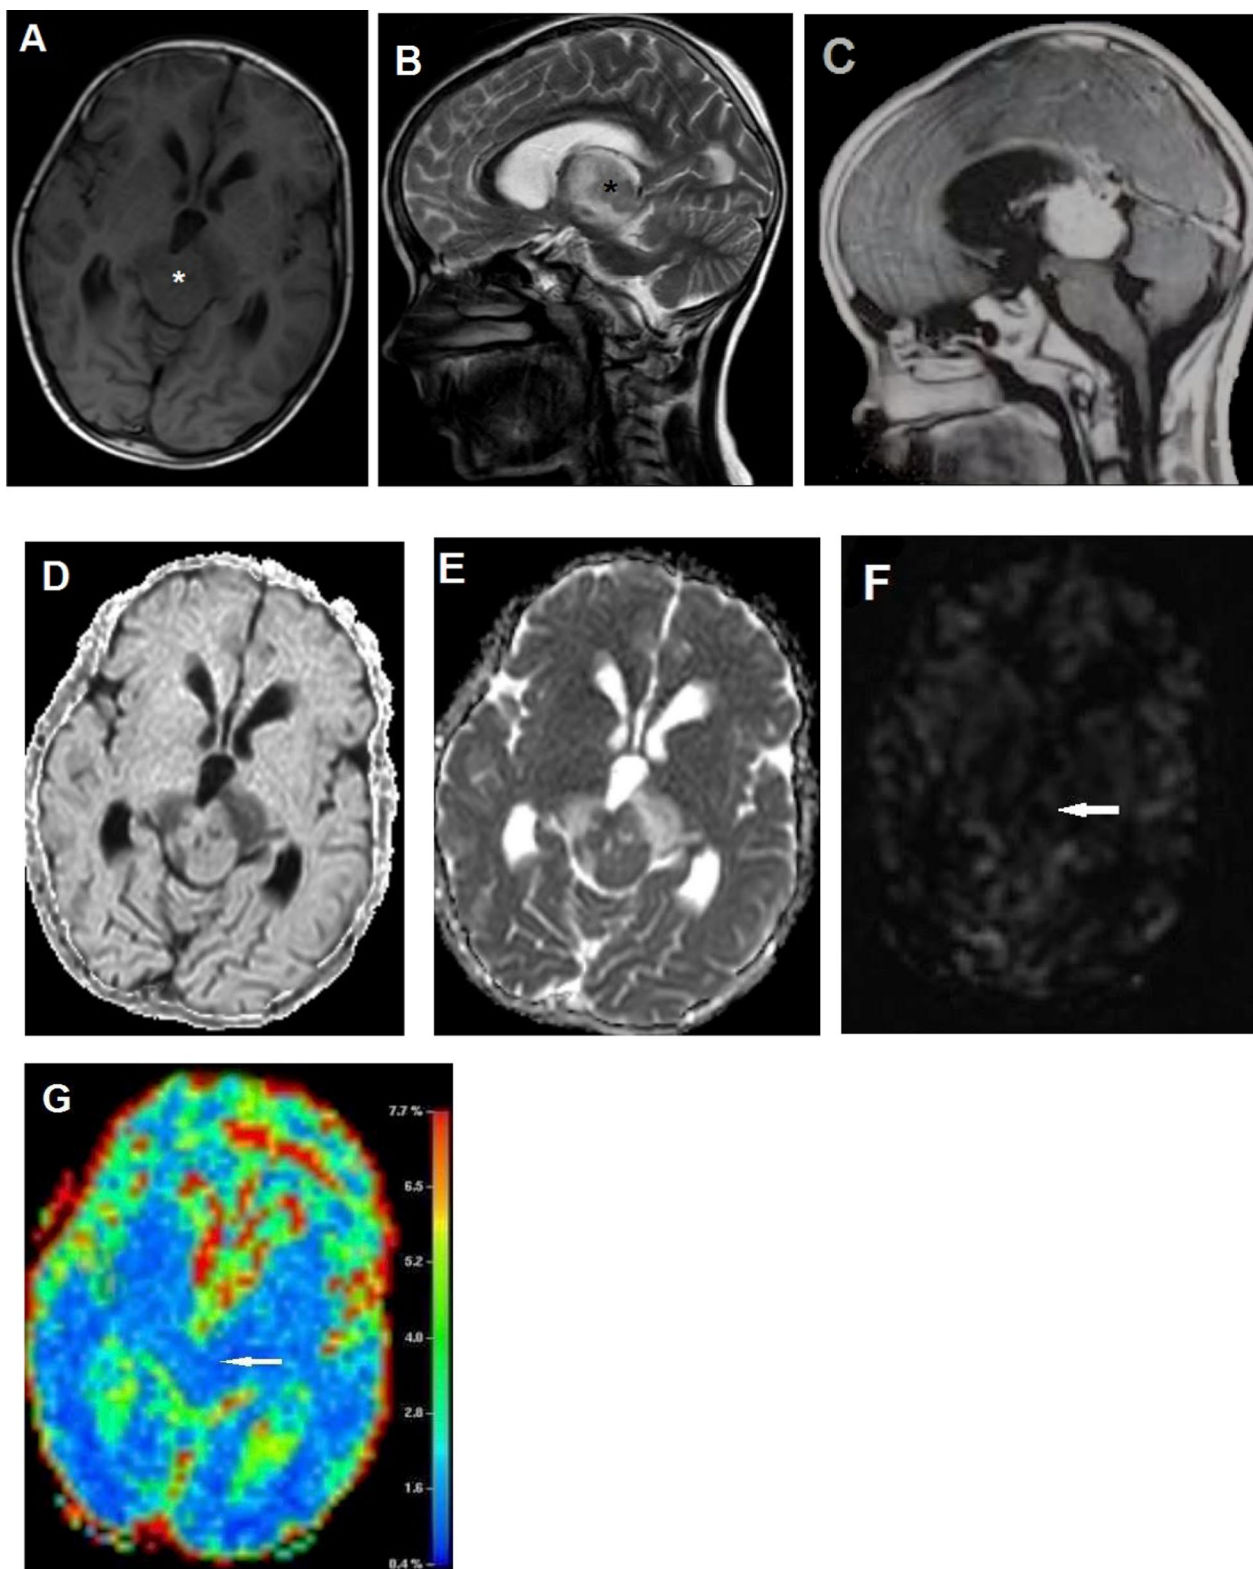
A 10-year-old boy patient with a WHO grade 2 pineal body tumor of intermediate differentiation. Images show a well-defined pineal body lesion with supra-tentorial hydrocephalic changes. It displays low signal intensity on axial T1WI (A) and intermediate to high SI with high SI perilesional edema on sagittal T2WI (B). It shows strong homogenous enhancement on post contrast sagittal T1WI (C), the lesion shows free diffusion as shown on both DWI (b1000 image) and axial ADC grayscale map (D,E). Hypo-perfusion of the lesion (white arrows) is demonstrated in the axial ASL grayscale and color CBF maps (F, G)
